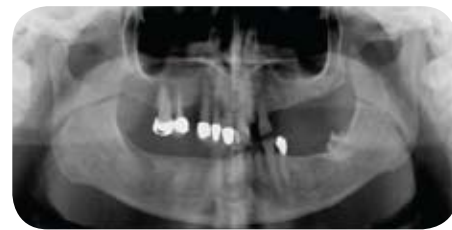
Panoramic radiograph reveals radiolucency at the anterior right maxilla. Observe residual roots of teeth that had been ground down to the gingival level by the previous dentist to avoid extraction.
